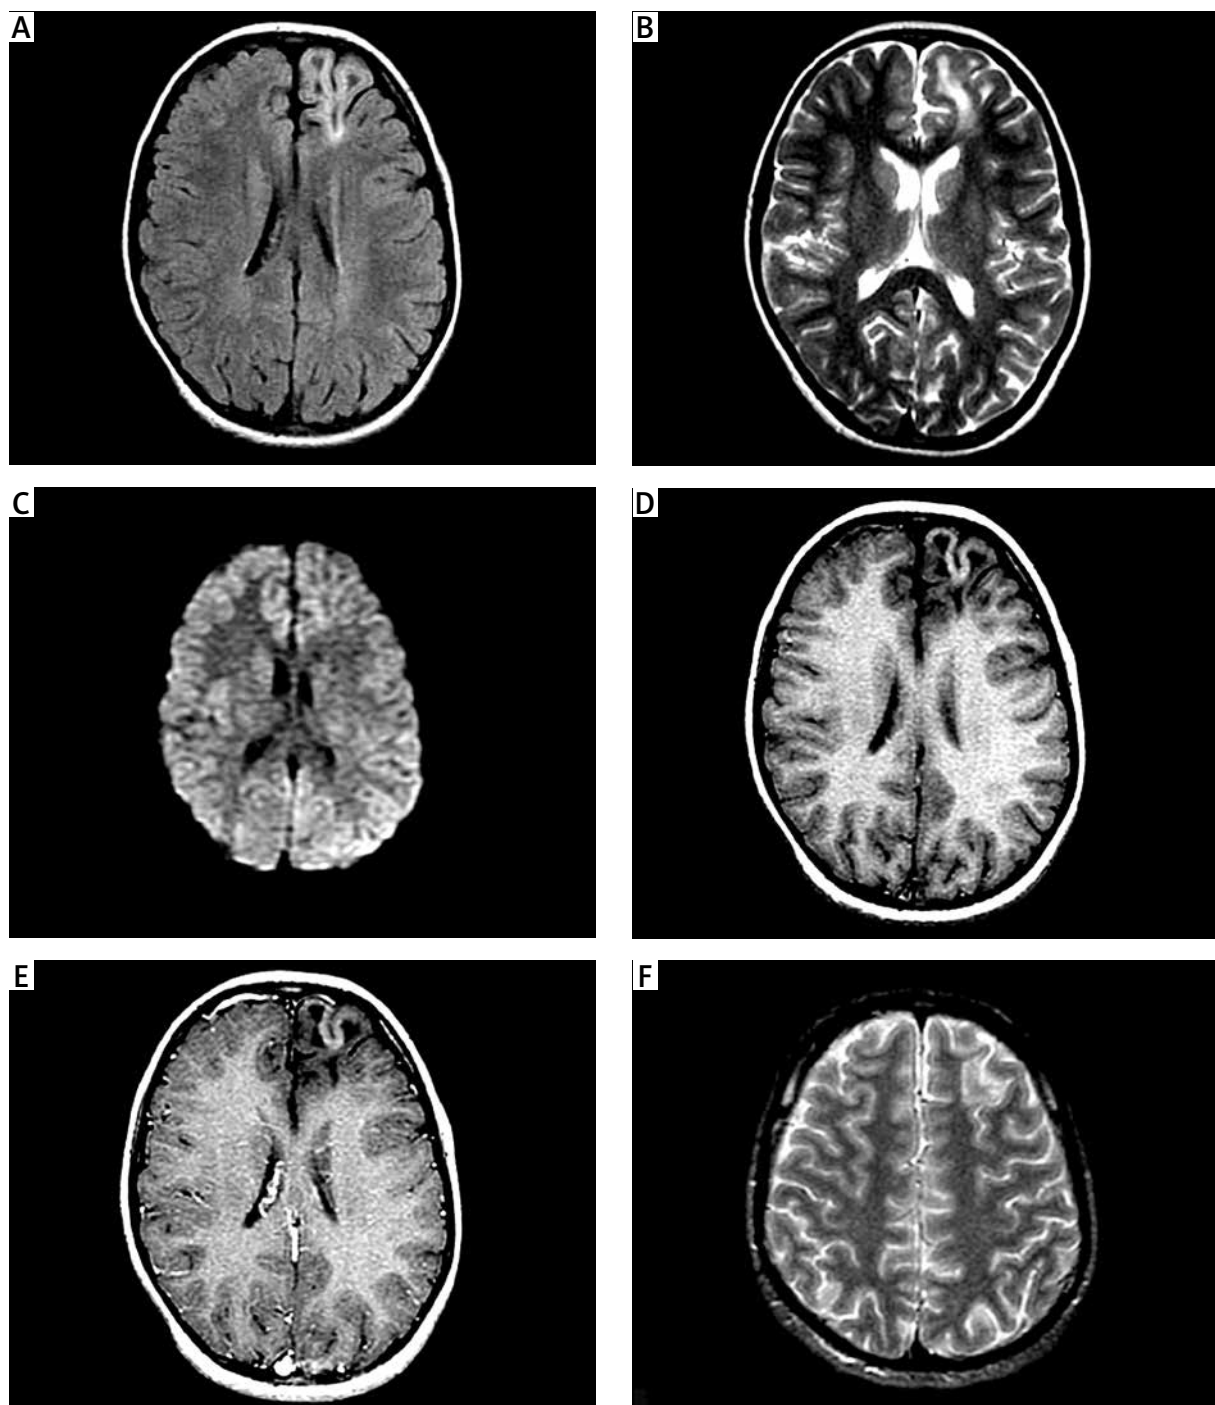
Magnetic resonance imaging. Case No 1. A) Partially hyperintense cortically based lesion in the left frontal lobe. MRI; axial plain; FLAIR sequence. B) Hyperintense lesion with stalk-like extension toward the ventricle. MRI; axial plain; frFSET2 sequence. C) No evidence of restriction diffusion inside the lesion. MRI; axial plain; DWI sequence. D) Ribbon-like hyperintense rim. MRI; axial plain; SET1 sequence. E) No enhancement inside the tumor. MRI; axial plain; postcontrast SET1. F) Case No 2. Slightly bubbly hyperintense lesion in the frontal lobe, without evidence of expansion. MRI; axial plain; frFSET2.
